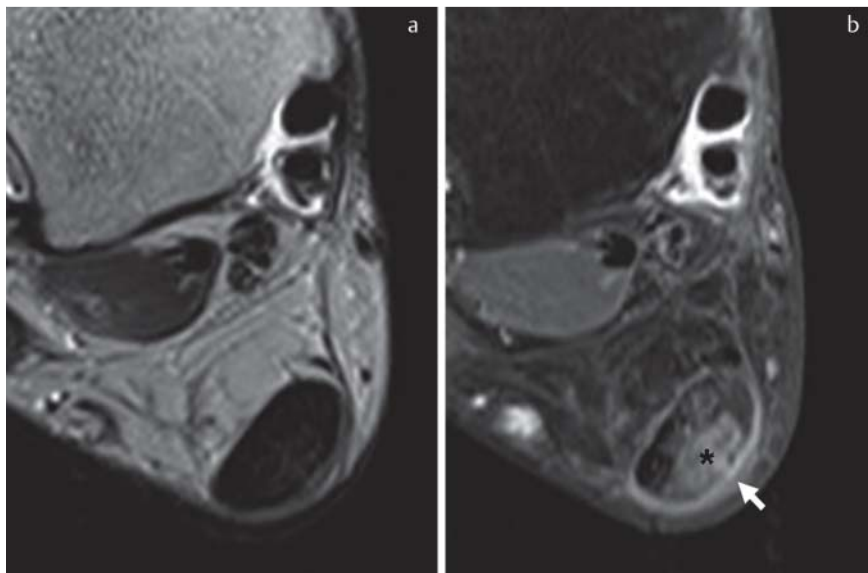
a PD-weighted axial image of a 46-year-old patient with mid-portion tendinosis. In comparison, b shows a contrast-enhanced axial T1-weighted image with fat saturation. Distinct intratendinous and paratendinous contrast enhancement (black asterisk and white arrow) is present.
